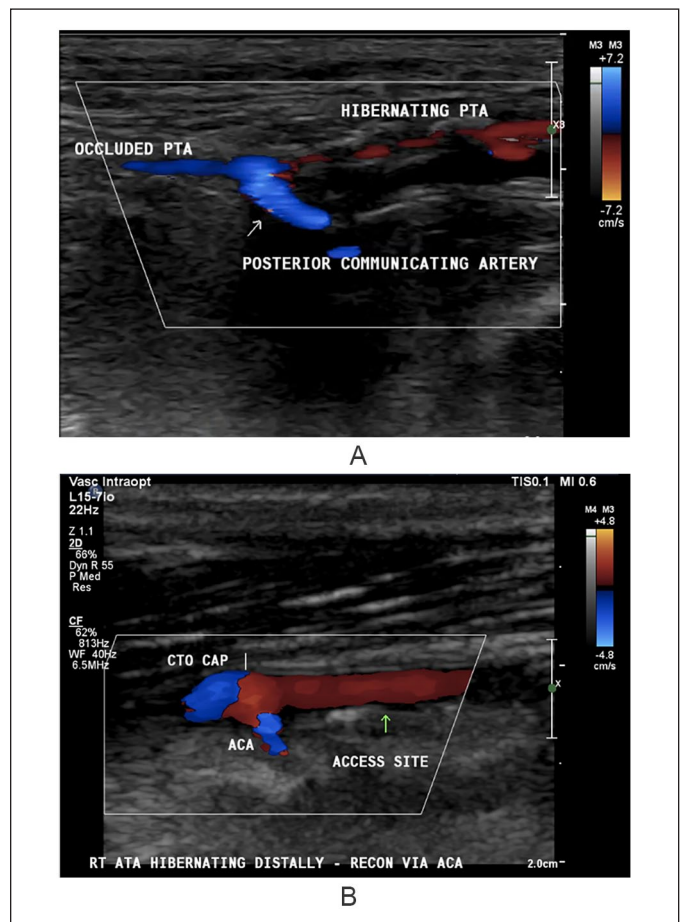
(A) Ultrasound view demonstrating a patent posterior communicating artery from the peroneal artery to the posterior tibial artery; (B) ultrasound view demonstrating a patent anterior communicating artery from the peroneal artery to the anterior tibial artery. Note. ACA = anterior communicating artery.
